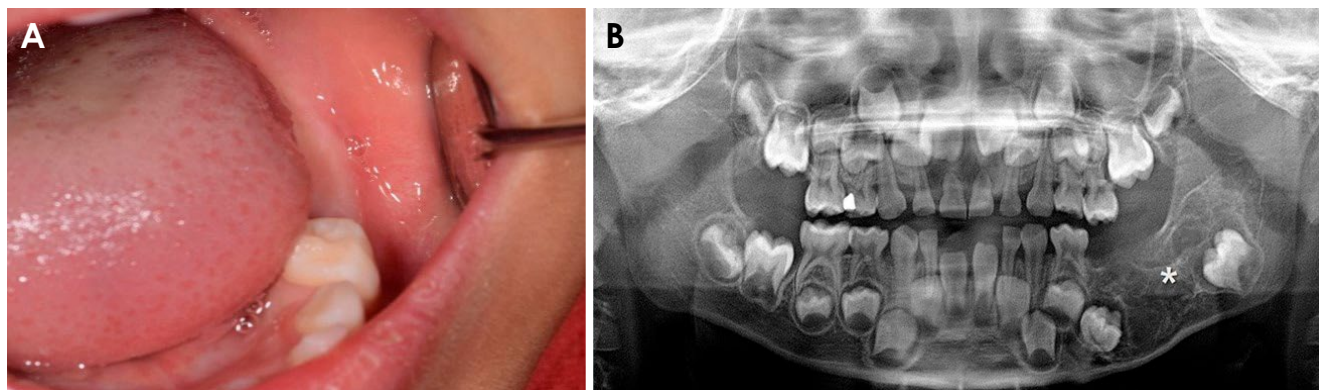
A. Intraoral photograph reveals missing teeth in the left mandibular posterior region. B. Panoramic radiograph shows a multilocular mixed lesion characterized by internal septa, calcified foci, and the displacement of the left deciduous and permanent molars (asterisk).
